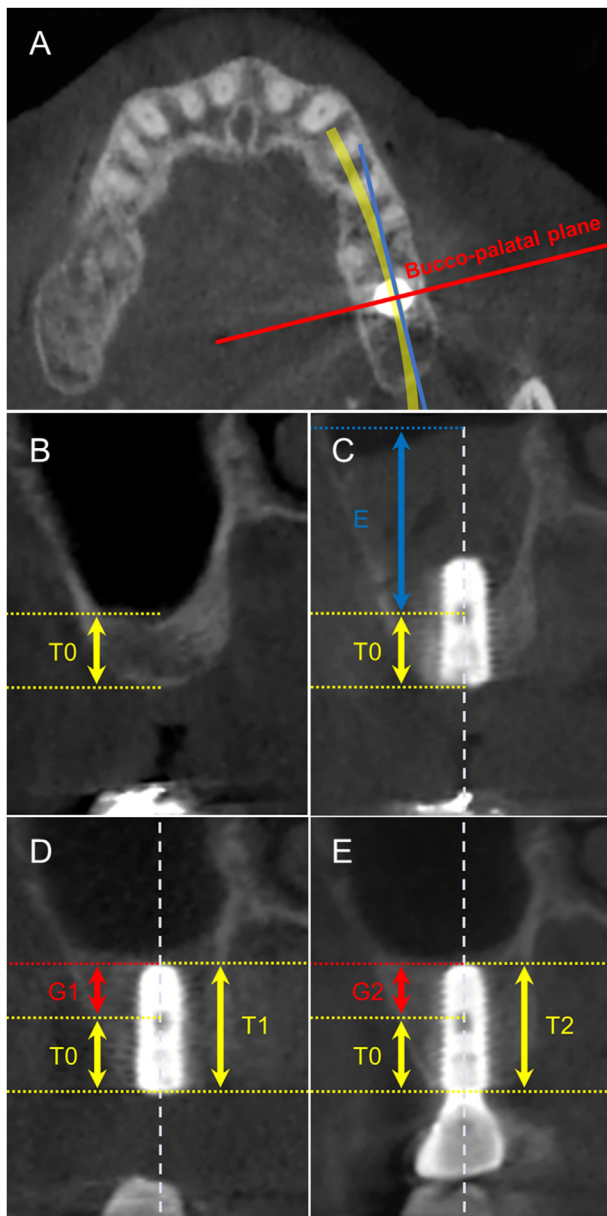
Two-dimensional bone height analysis of sinus floor elevation using absorbable collagen sponge. (A) Selection of the buccopalatal plane for radiographic evaluation. An arc is drawn along the contours of the maxillary arch in the axial view, and a tangent is drawn to the arc where it meets the center of the implant. The buccopalatal plane is established perpendicular to the tangent line and parallel to the long axis of the implant. (B) Preoperative cone-beam computed tomography view. (C) Residual bone height and sinus membrane elevation height measured after implant installation. (D) New bone formation at 6 months postoperatively. (E) New bone formation at 12 months postoperatively. E, sinus membrane elevation height; T0, residual bone height; T1, new bone height at 6 months postoperatively; T2, new bone height at 12 months postoperatively; G1, bone height change at 6 months postoperatively; G2, bone height change at 12 months postoperatively.
